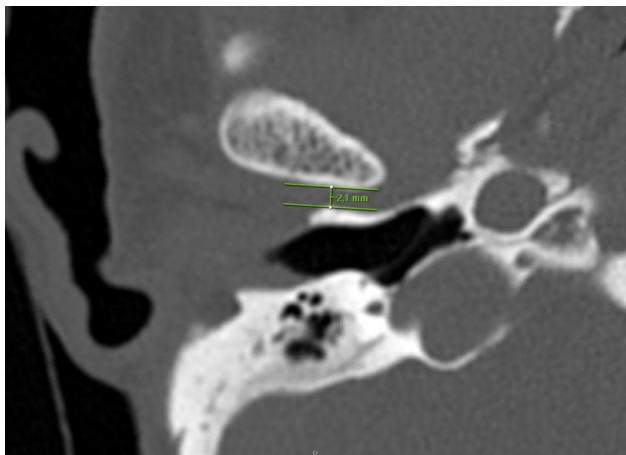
Temporal CT image of a 31-year-old man (Right JSWTT)
